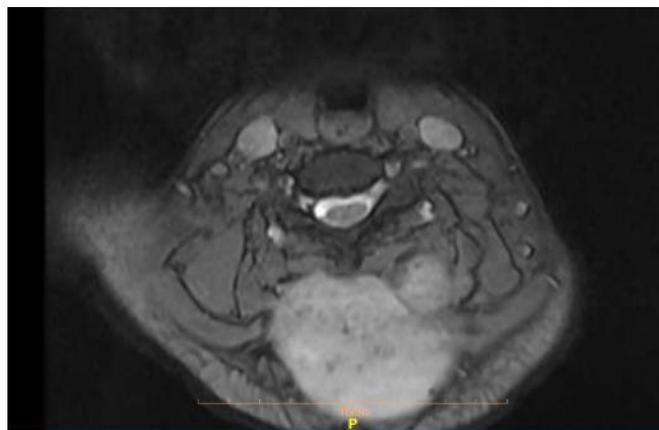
Axial magnetic resonance imaging of the mass
